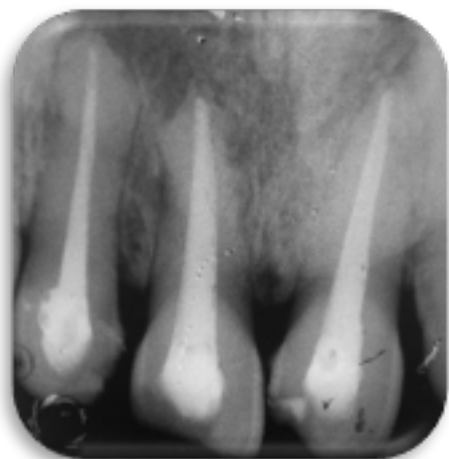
Post-operative intraoral periapical radiograph showing obturation in 12, 11 and 21.
